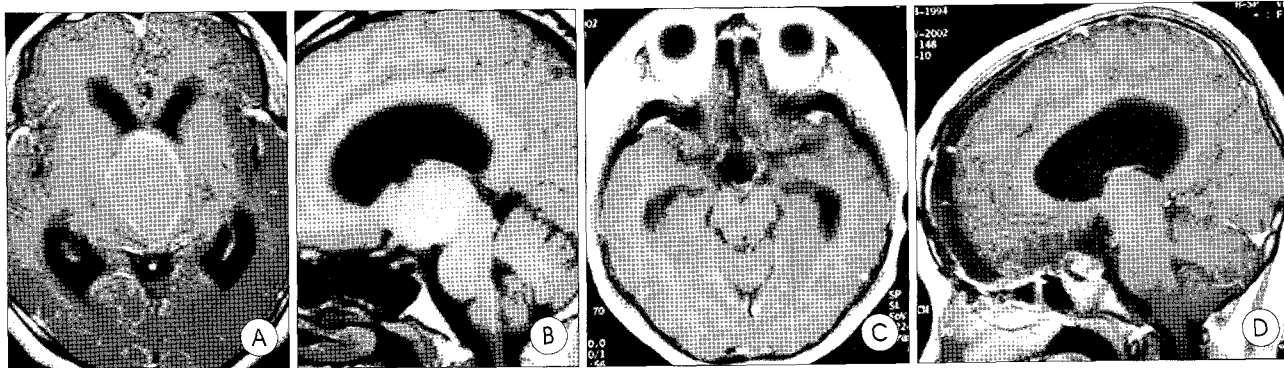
Axial T1-weighted gadolinium-enhanced magnetic resonance image (A) and sagittal image (B) showing a homogenous sellar and suprasellar mass with the compression of the third ventricle. Postoperatively, total removal of the tumor is shown (C & D).
